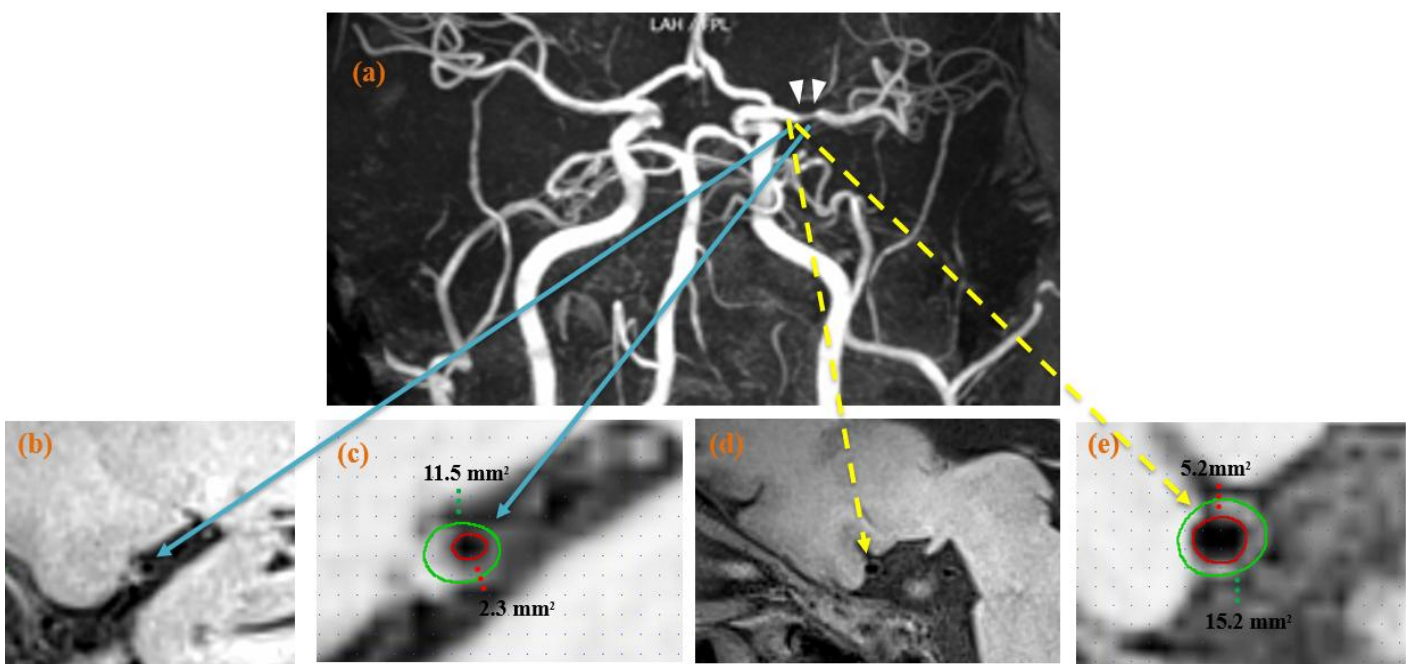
(a-e) Intracranial atherosclerotic plaque identified on the HR-MRI. Among these impinges, Fig. (a) shows the left MCA (M1) with significant luminal narrowing on MRA (white arrow). T1-weighted sagittal images, reconstructed from 3D high-resolution MRI acquisition, were utilized for lesion analysis (b, c) and reference site analysis (d, e). These images were orthogonal to the left M1 segment of the middle cerebral artery (MCA). The lesion locations were identified by arrows (blue solid line and arrows) on the MRA, while the reference site locations were indicated by arrowheads (yellow dotted lines and arrows). Contours were drawn to delineate the outer wall of the vessel (green) and lumen (red) of the nearest plaque-free or minimum lesion segment proximal to the lesion, which was selected as reference sites (d), and the cross section with the thickest plaque was selected as the maximum luminal narrowing (MLN) site (c). The reference vessel area was calculated as the luminal area at the proximal site due to vessel tapering. The remodeling index (RI) was computed as the vessel area at the MLN site divided by the reference vessel area $11.5/15.2 = 0.75$, indicative of negative remodeling.
